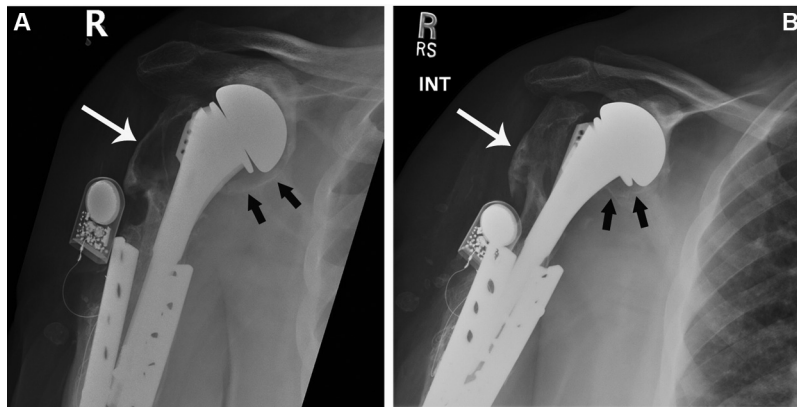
Anteroposterior radiographs (A) at presentation and (B) 5 years earlier showing long-standing modular humeral hemiarthroplasty with standard-length stem in place with an adjacent old healed humeral shaft fracture status post-treatment with metallic double-plating and compression technique and direct current electrical bone stimulator placement. Worsening osteolysis at humeral greater tuberosity (long arrow) and scapular glenoid (short arrows) appears over time.
